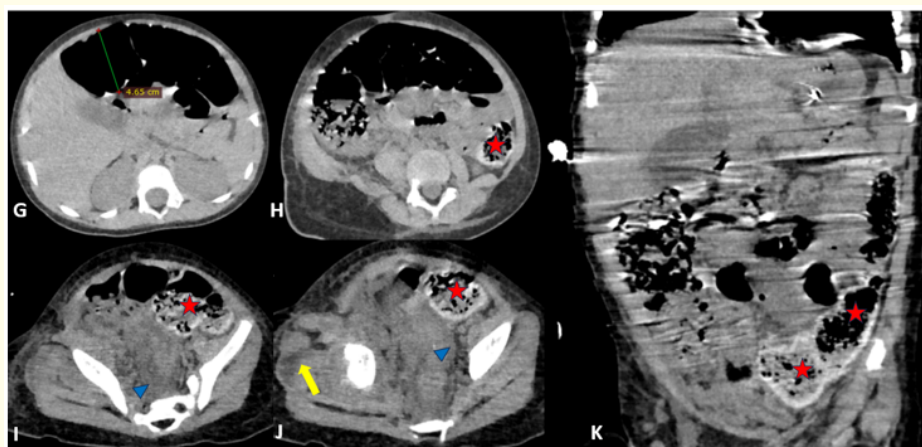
Abdominal CT findings in a 9-month-old infant with disseminated *Staphylococcus aureus* infection. Unenhanced axial CT images (G-J) and coronal reconstruction (K) demonstrate marked bowel distension (G), associated with segmental circumferential bowel wall thickening and spontaneous mural hyperattenuation (red stars), suggesting a possible hemorrhagic component. Associated diffuse edematous changes of the abdominopelvic soft tissues are also present (blue arrowheads), along with the known gluteal soft-tissue abscess (yellow arrow). No definite pneumatosis intestinalis or pneumoperitoneum is identified. Intravenous contrast was not administered because of acute kidney injury, precluding assessment of bowel wall enhancement and mesenteric perfusion.
